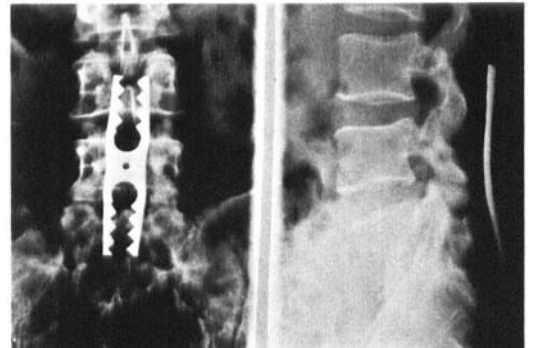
Anteroposterior and lateral radiographs of acute traumatic subluxation of the fifth lumbar vertebra after reduction and posterior fusion with internal fixation; the Daab plate secured two-level fusion.
